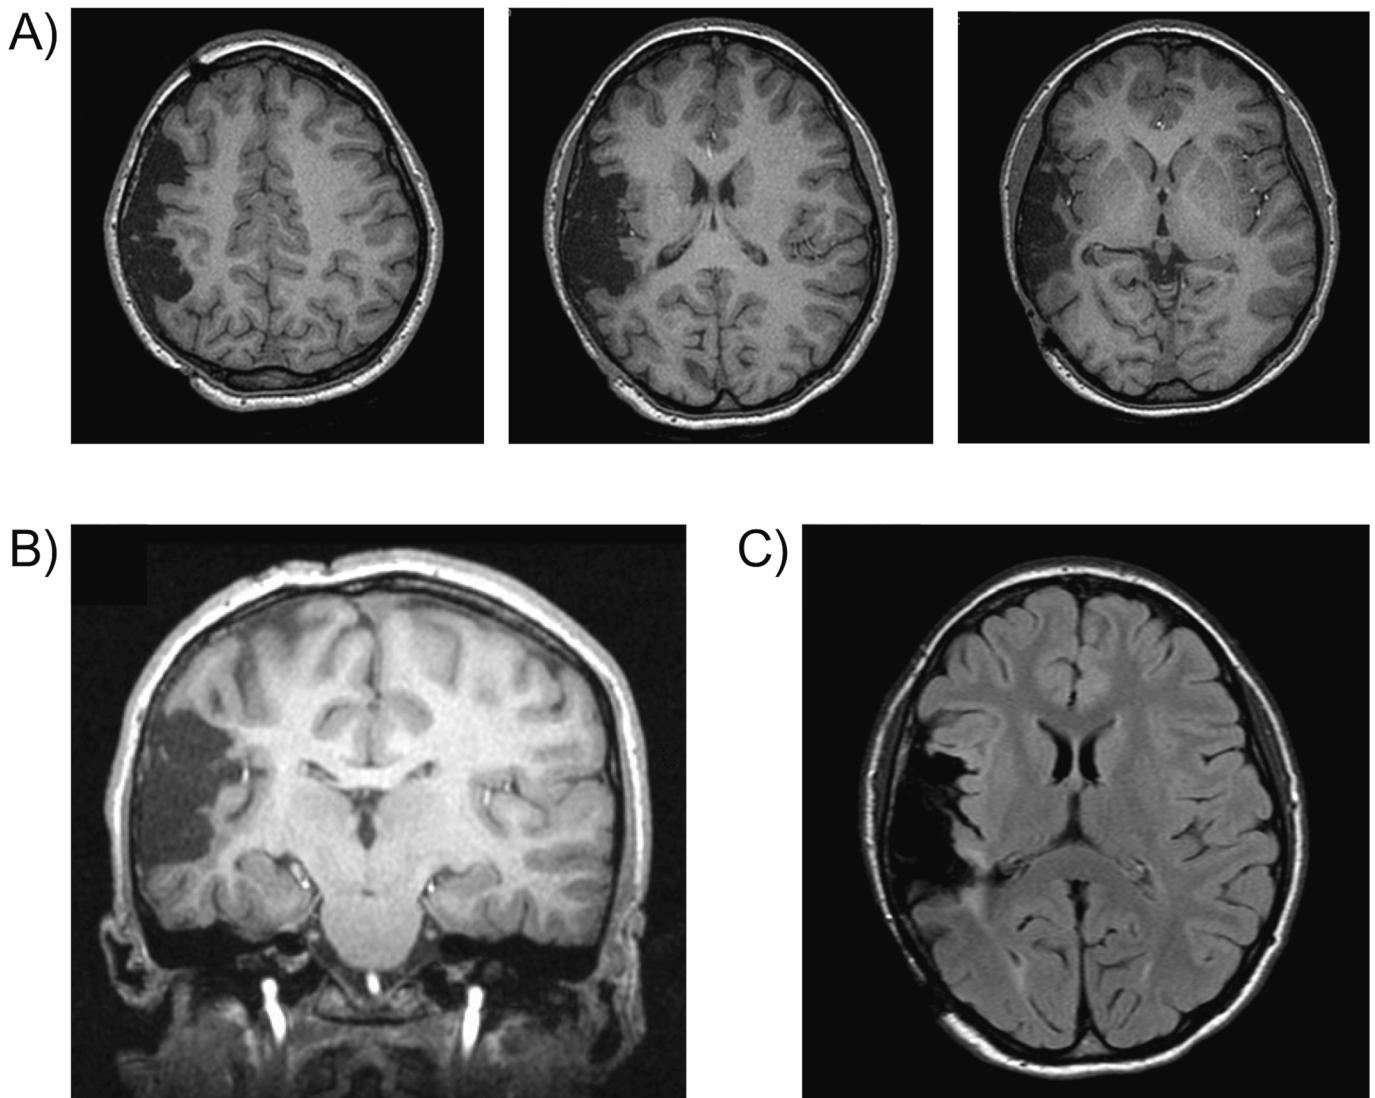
Magnetic resonance imaging completed at 11 years old revealing anticipated post-surgical changes after cortical excision of the right superior temporal gyrus and right inferior Rolandic region, as well as possible residual cortical dysplasia involving the inferior right precentral gyrus. Area of excised cortex can be seen on (A) serial axial T1 images progressing superiorly to inferiorly, (B) coronal T2 image, and (C) axial FLAIR image.
